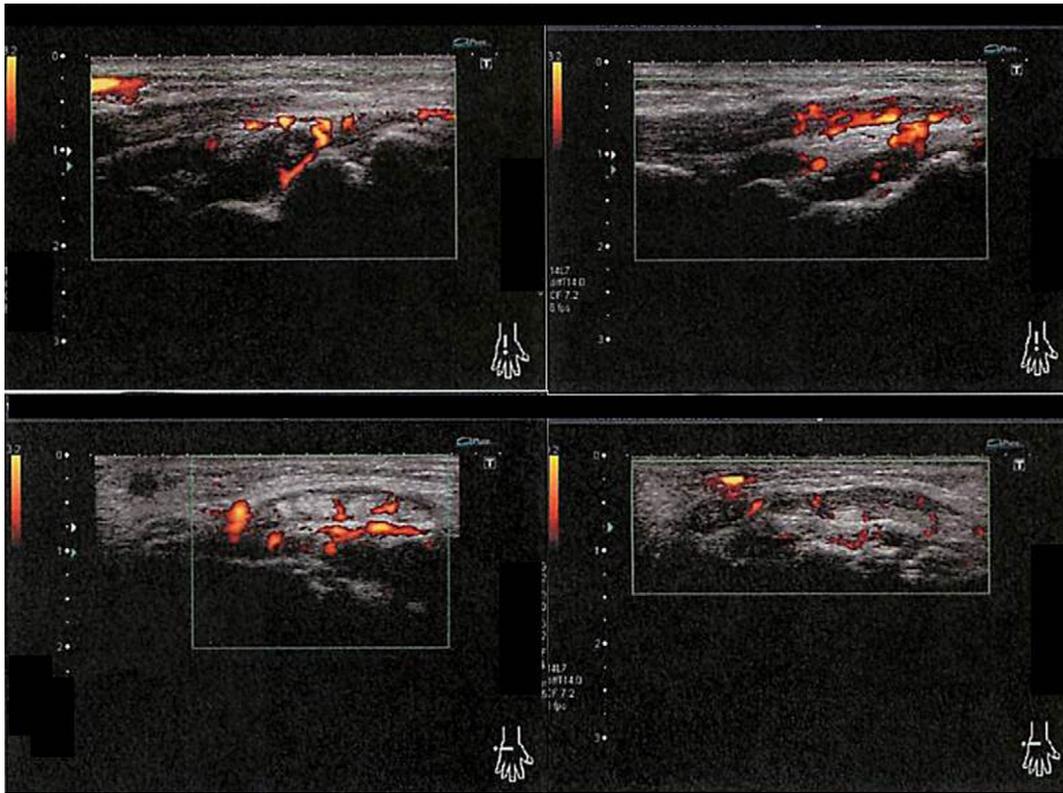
Hand ultrasound examination performed on admission showing a power Doppler signal compatible with tenosynovitis and subcutaneous edema of the right wrist joint.
